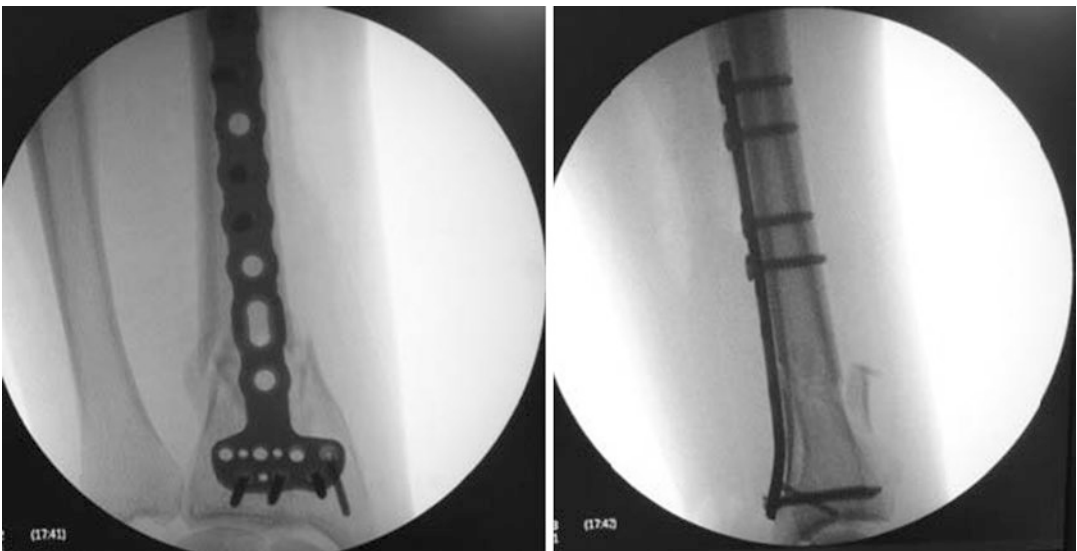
Radiographic assessment. The radial length and alignment are correct. The plate is bridging the comminuted metaphyseal area
